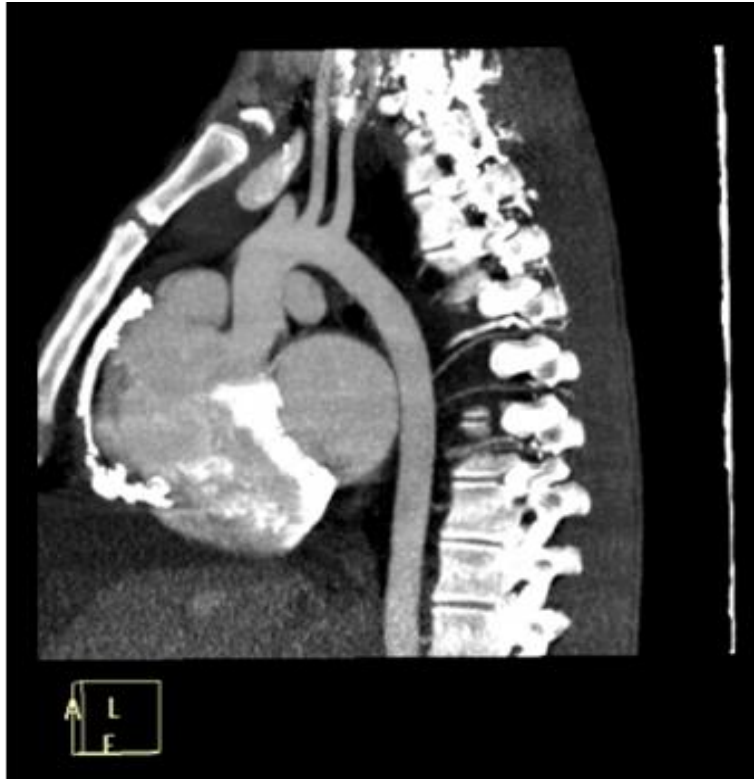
CT Lateral view of the heart.
